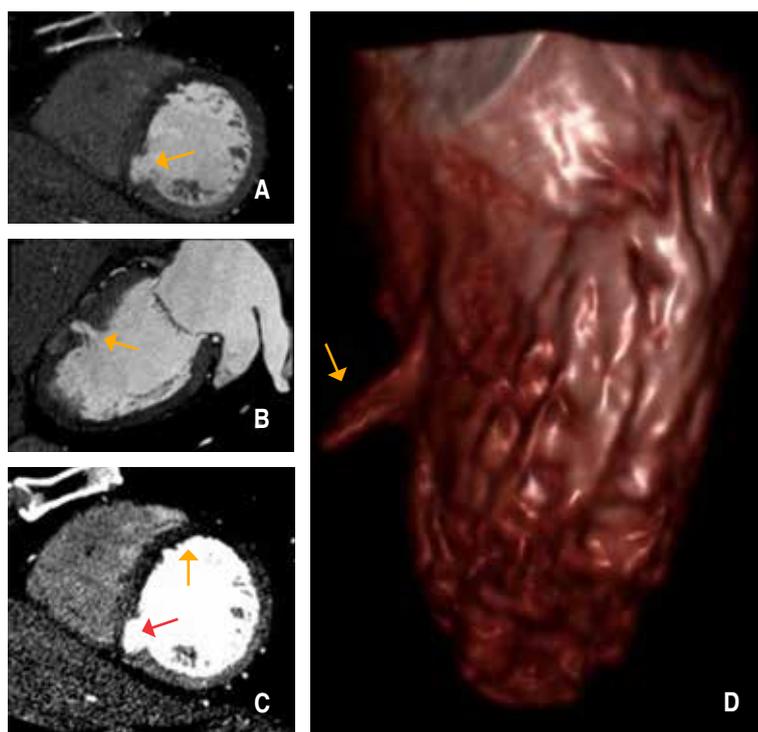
Coronary computed tomography angiography revealing a left ventricular diverticulum. A & B) Two-chamber view (arrow). C) Two-chamber view: Perfusion defect in the anterior and anteroseptal wall at the mid-segment (arrow). Ventricular diverticulum adjacent to ischemic myocardial tissue (red arrow). D) 3D reconstruction of left ventricular volume (arrow).
